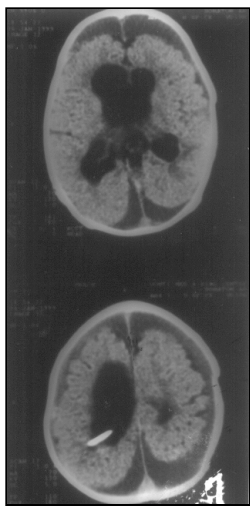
CT head depicting subdural fluid collection following right ventriculoperitoneal shunt in an hydrocephalic child. Choroid plexus papilloma from lateral ventricle had been excised before shunt in this child.
